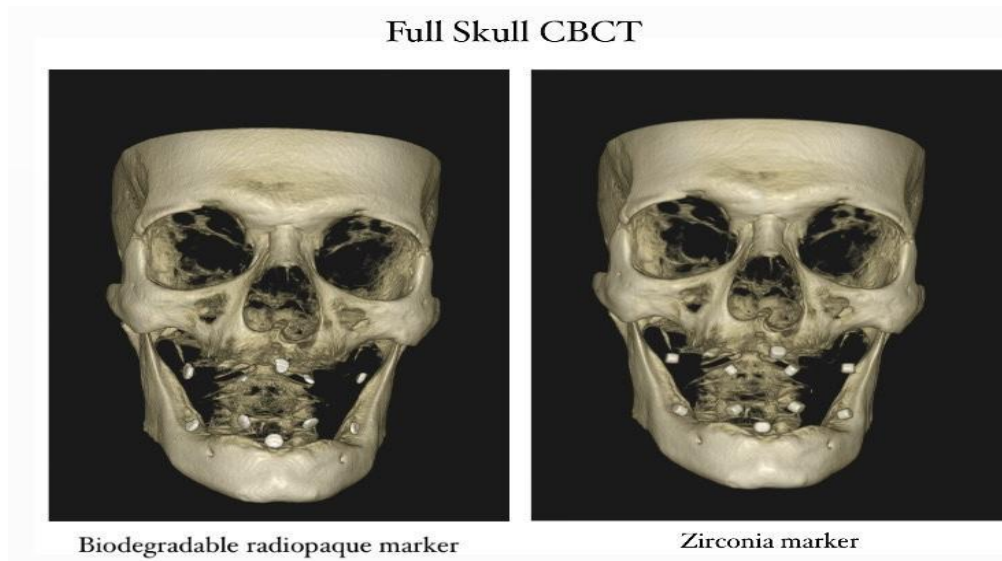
Full skull CBCT of the biodegradable radiopaque marker and zirconia marker
